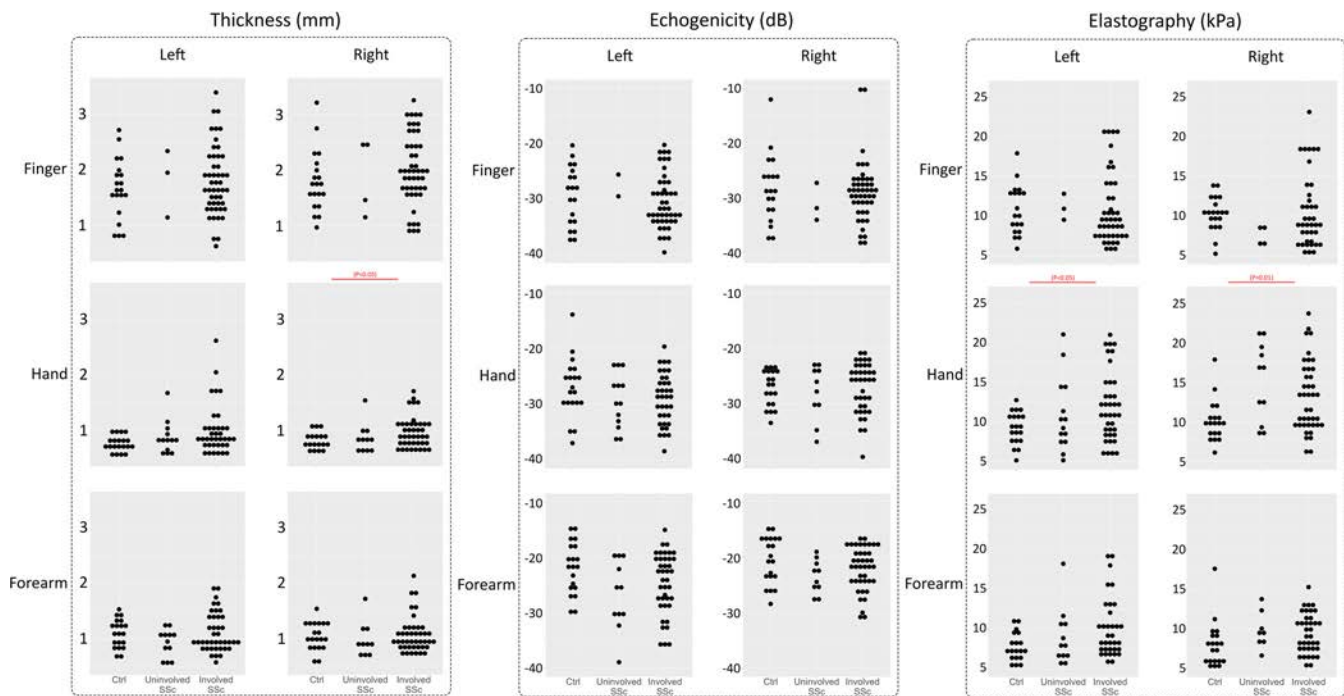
Ultrasound-based measurements in patients with SSc and Ctrl. Ultrasound-based measurement of dermal thickness, echogenicity, and elastography are shown in Ctrl skin, unaffected SSc skin (local skin score = 0), and affected SSc skin (local skin score ≥1) for left and right finger, hand, and forearm body areas. Ctrl, healthy controls; SSc, systemic sclerosis.
